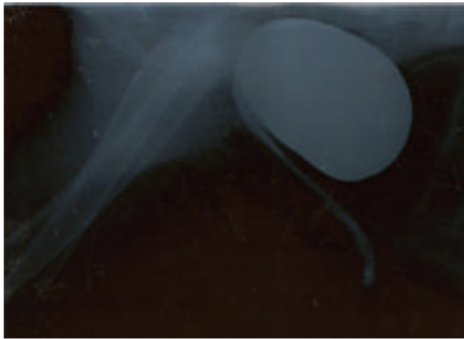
The radiographic appearance of urethral jejunal segment and vesica urinaria (4th month)
